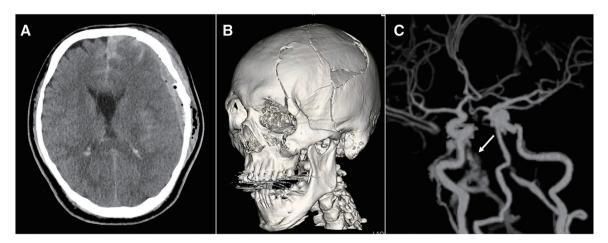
Images from Case 1 on arrival at the hospital. (A and B) Initial CT when the patient was transferred. A left acute subdural hemorrhage and multiple skull fractures were detected. (C) Initial 3D-CTA. The venous system was depicted around the right internal carotid artery (arrow), which implied the emergence of shunt flow.
